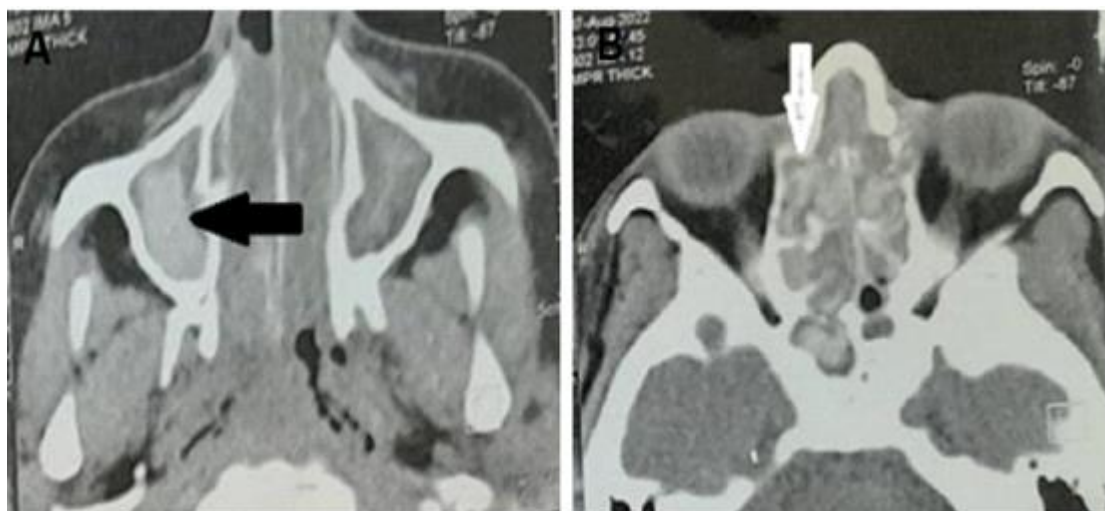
Axial CT soft tissue window at the level of maxillary (A) and ethmoidal (B) sinuses shows complete opacified examined nasal sinuses with areas of hyperdenisty inside the center of the sinuses (arrow black and white) with no bony erosions. Also noted hypertrophied nasal turbinates
